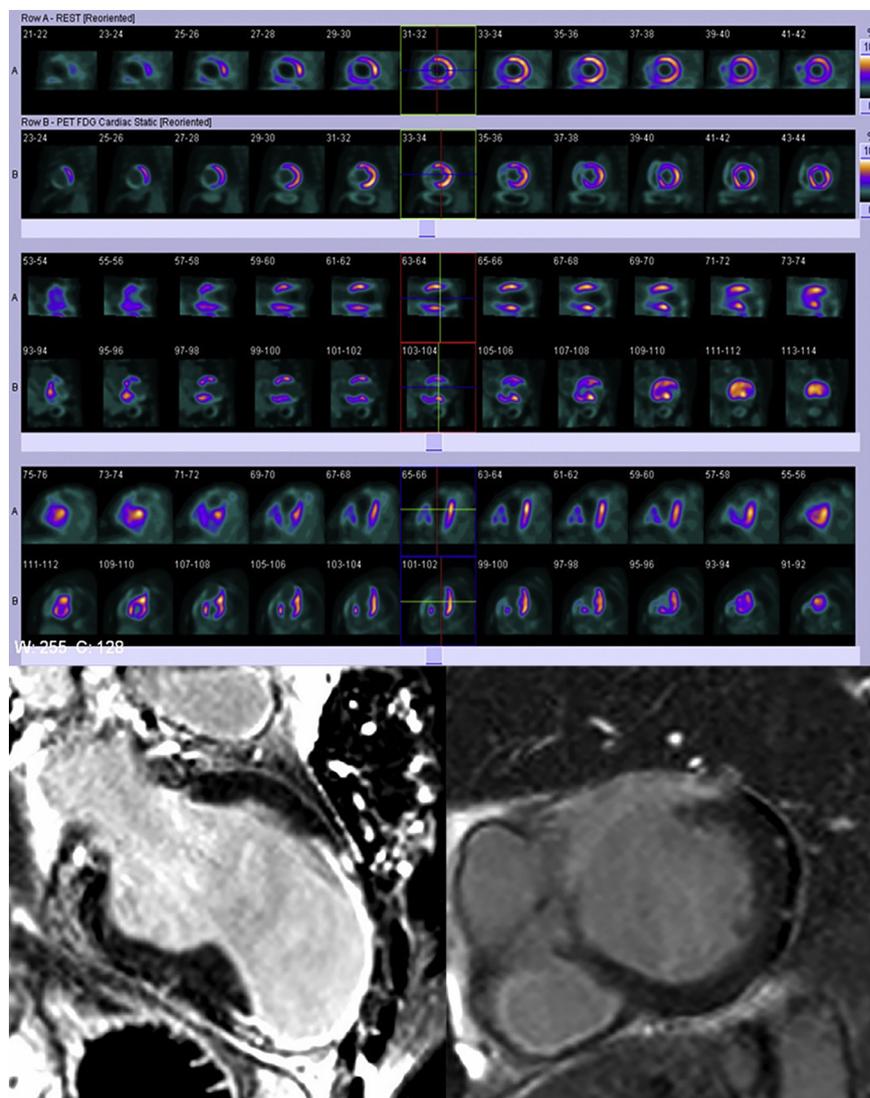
In a patient with chronic total occlusion of the LAD artery, short axis, horizontal long axis, and vertical long axis SPECT perfusion (top row) and ^{18}F -FDG PET (bottom row) images showed the apex, all myocardial segments of the apical and septal wall had severe defects (matched) and short axis and vertical long axis cardiac MRI images showed that LGE of corresponding myocardial segments was 76–100%.
